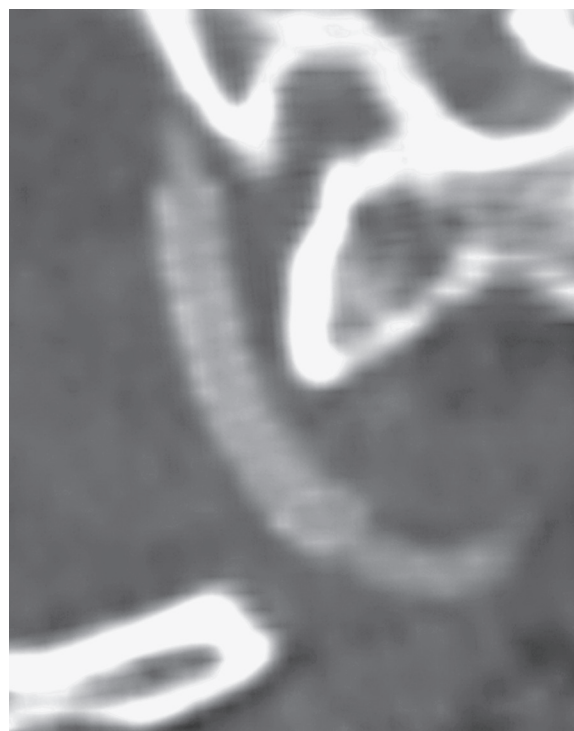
Three-month follow-up CTA showing aneurysm exclusion, a patent covered stent with no intimal hyperplasia, and aneurysm shrinkage.
